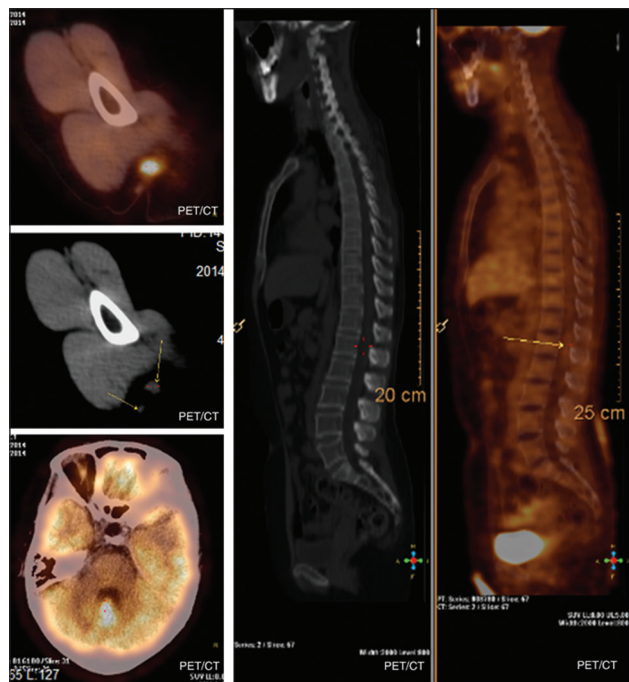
A positron emission tomography/computed tomography scan showed multiple nodules in the left shoulder
